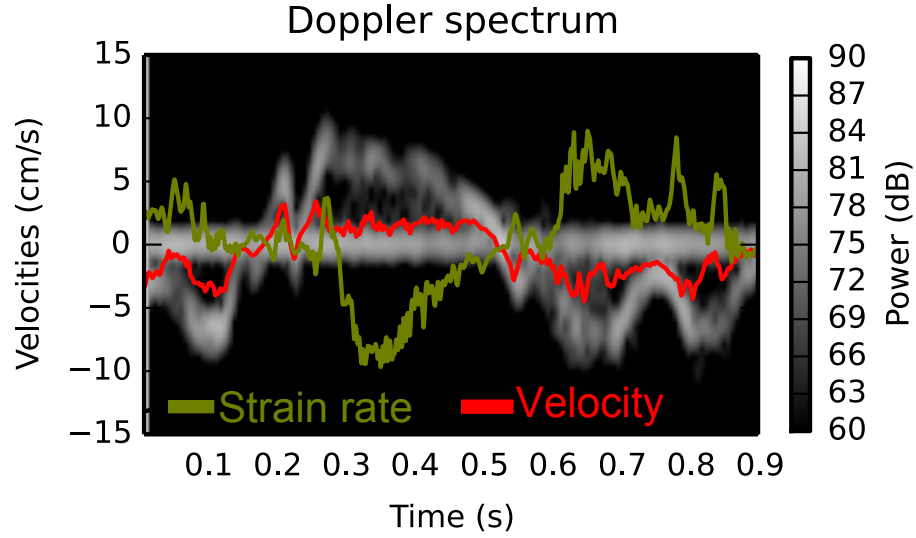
Doppler spectrum with velocity and strain rate estimations by autocorrelation from the basal septum. The Doppler spectrum was calculated with a window length of 30 ms. The velocity and strain rate measurements were estimated with plain autocorrelation. The velocity curves is biased towards zero due to clutter and the strain rate curve is noisy.
